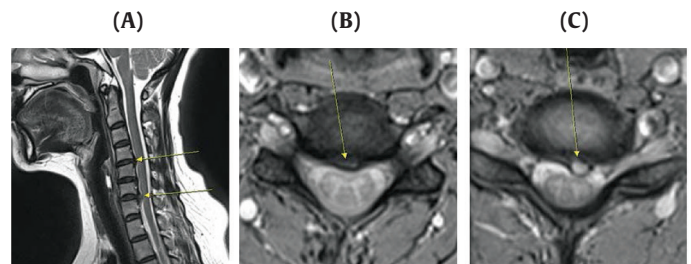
Cervical spine MRI (T2-weighted image) of Case 1 on June 12, 2017. (A) Sagittal (B) Axial C4-5 (C) Axial C6-7. MRI, magnetic resonance imaging.
